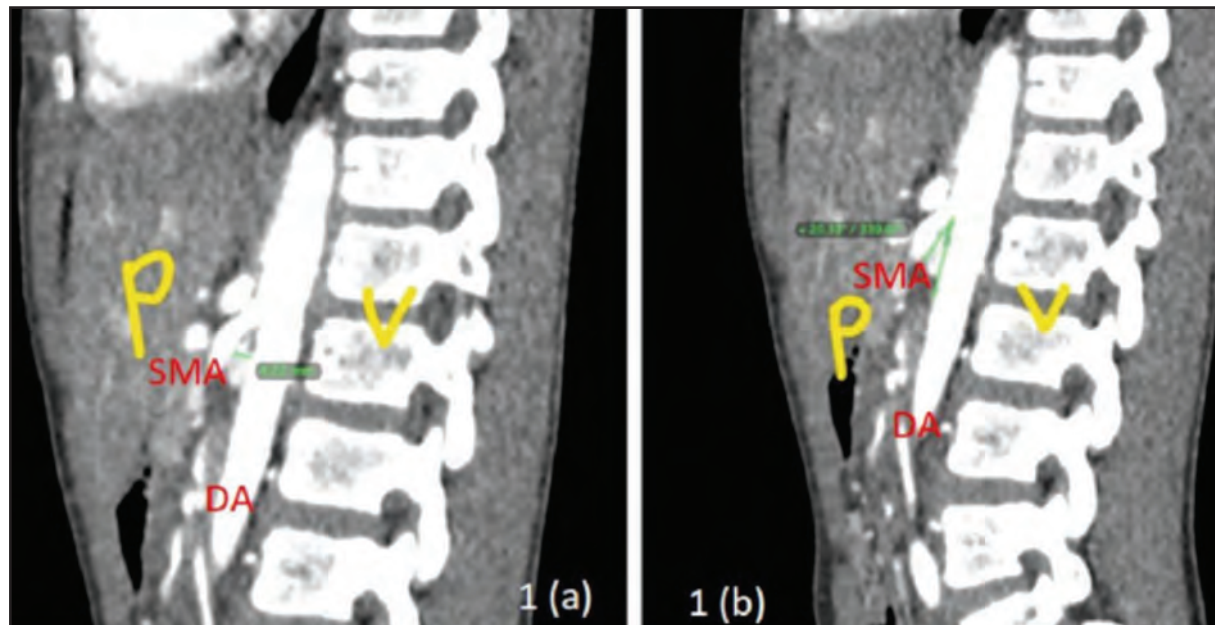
Sagittal view of CT angiogram. (a) shows aortomesenteric distance of 4.22mm. (b) shows aortomesenteric angle of 20.33 degree. P = Peritoneum; V = Vertebrae; SMA: Superior Mesenteric Artery; DA = Descending Aorta
